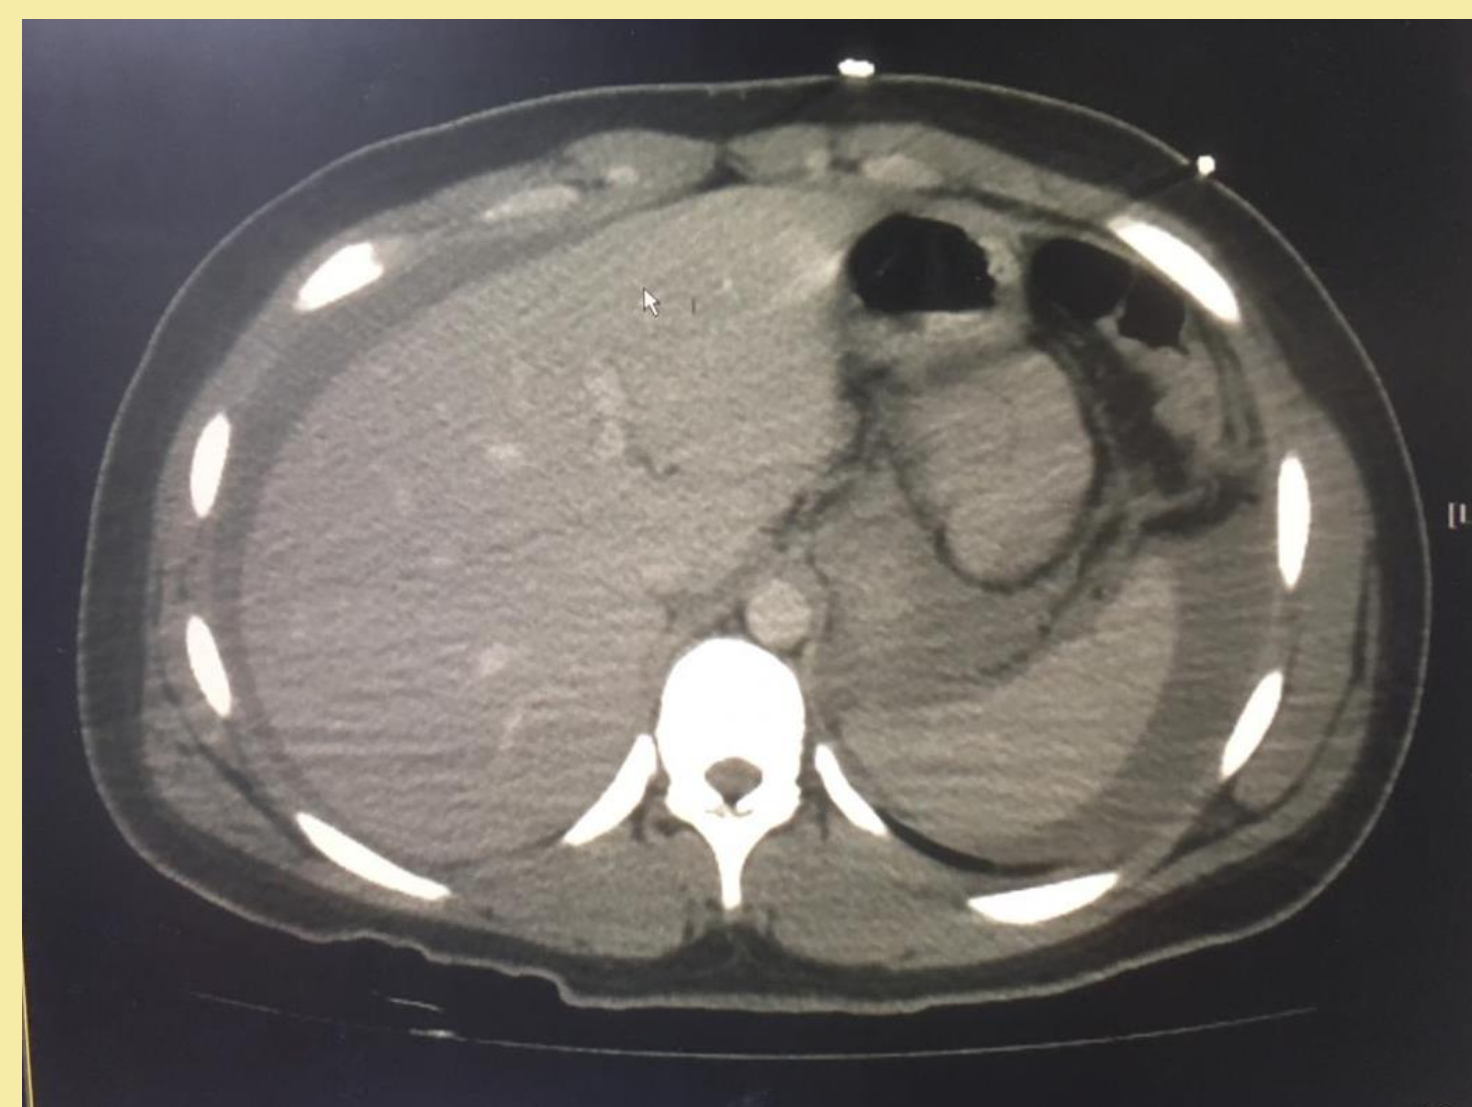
CT abdomen axial view showed hemoperitoneum
